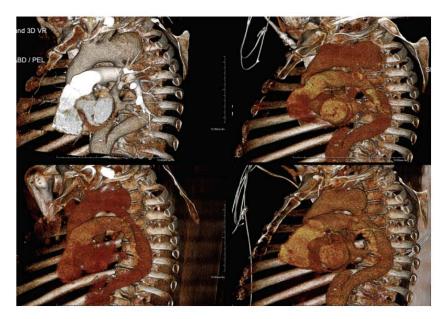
Computed tomography angiogram with 3D reconstruction of aorta and mycotic aneurysm
